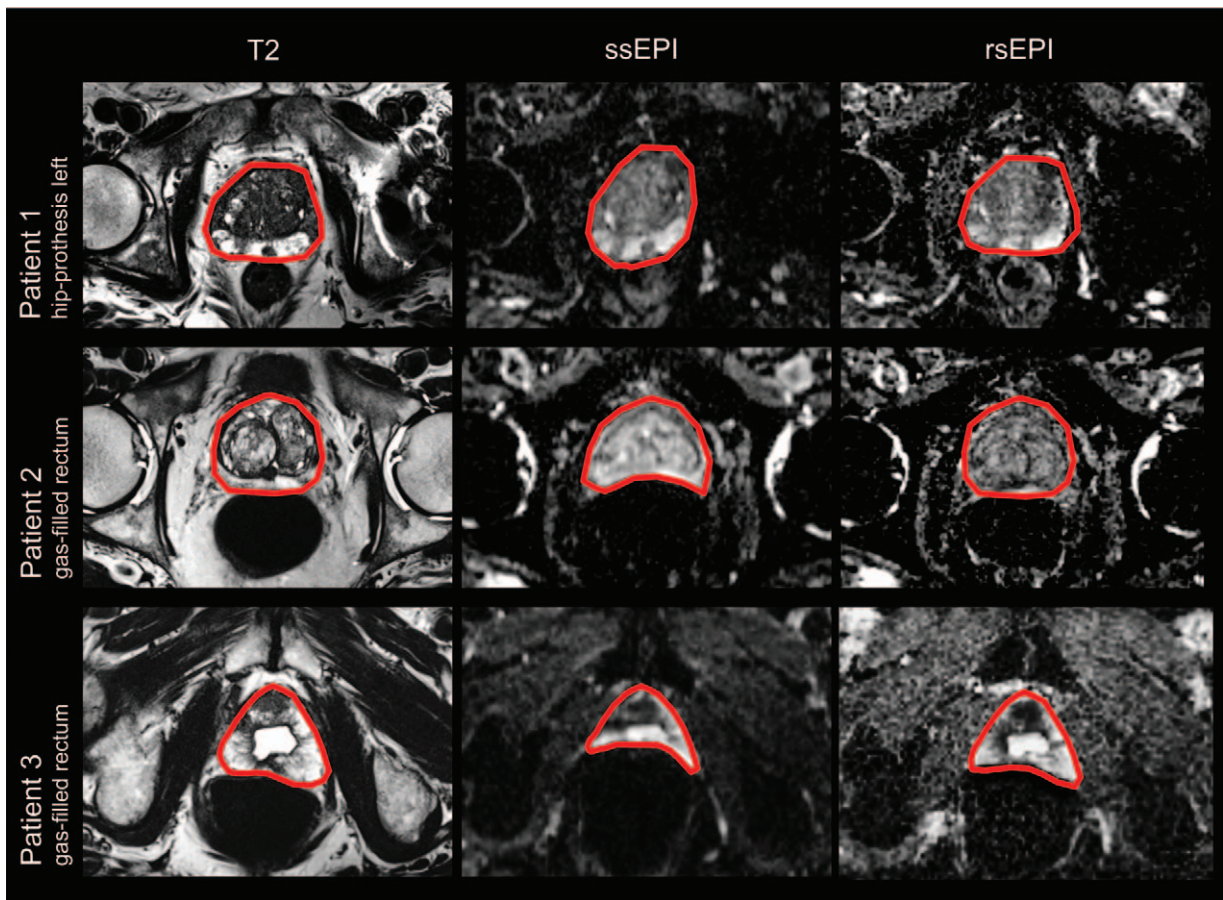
Visual comparison of rsEPI DWI and ssEPI DWI by means of MRI examinations from our collective. Depicted are 3 representative MRI examinations with challenging conditions for DWI. The prostate shape is delineated in red and agreement with T2 weighted images is better with rsEPI DWI than with ssEPI DWI. DWI=diffusion weighted imaging, MRI=magnetic resonance imaging, rsEPI=readout-segmented echoplanar, ssEPI=single-shot echoplanar imaging.
